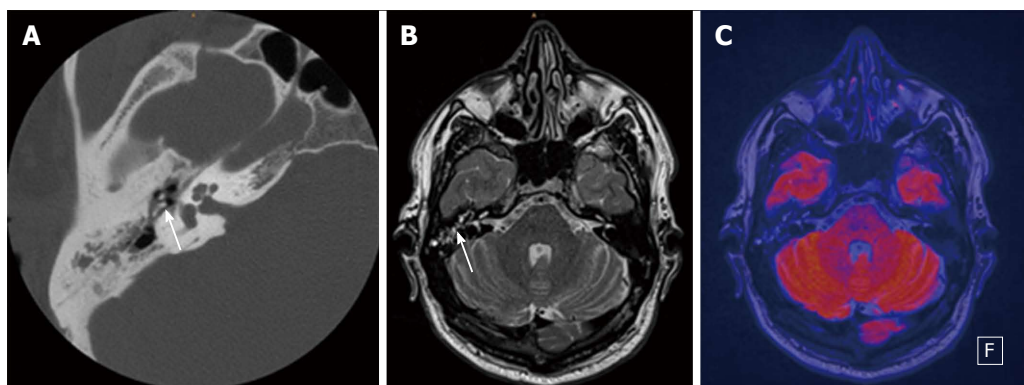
Thirty-nine-year-old male patient with clinically suspected cholesteatoma in the right middle ear. A: Axial CT of the temporal bone with soft-tissue mass in the tympanic space adjacent to malleolus and incus (white arrow); B: Axial T2-weighted MR depicts fluid-like signal in the tympanic space (white arrow); C: Fused axial T2-weighted image and axial EPI DWI RESOLVE without any sign of restriction. Therefore there is no evidence of cholesteatoma; the findings are consistent with chronic otitis media. CT: Computed tomography; DWI: Diffusion weighted imaging; EPI: Echo-planar imaging; RESOLVE: Readout-segmented echo-planar.
